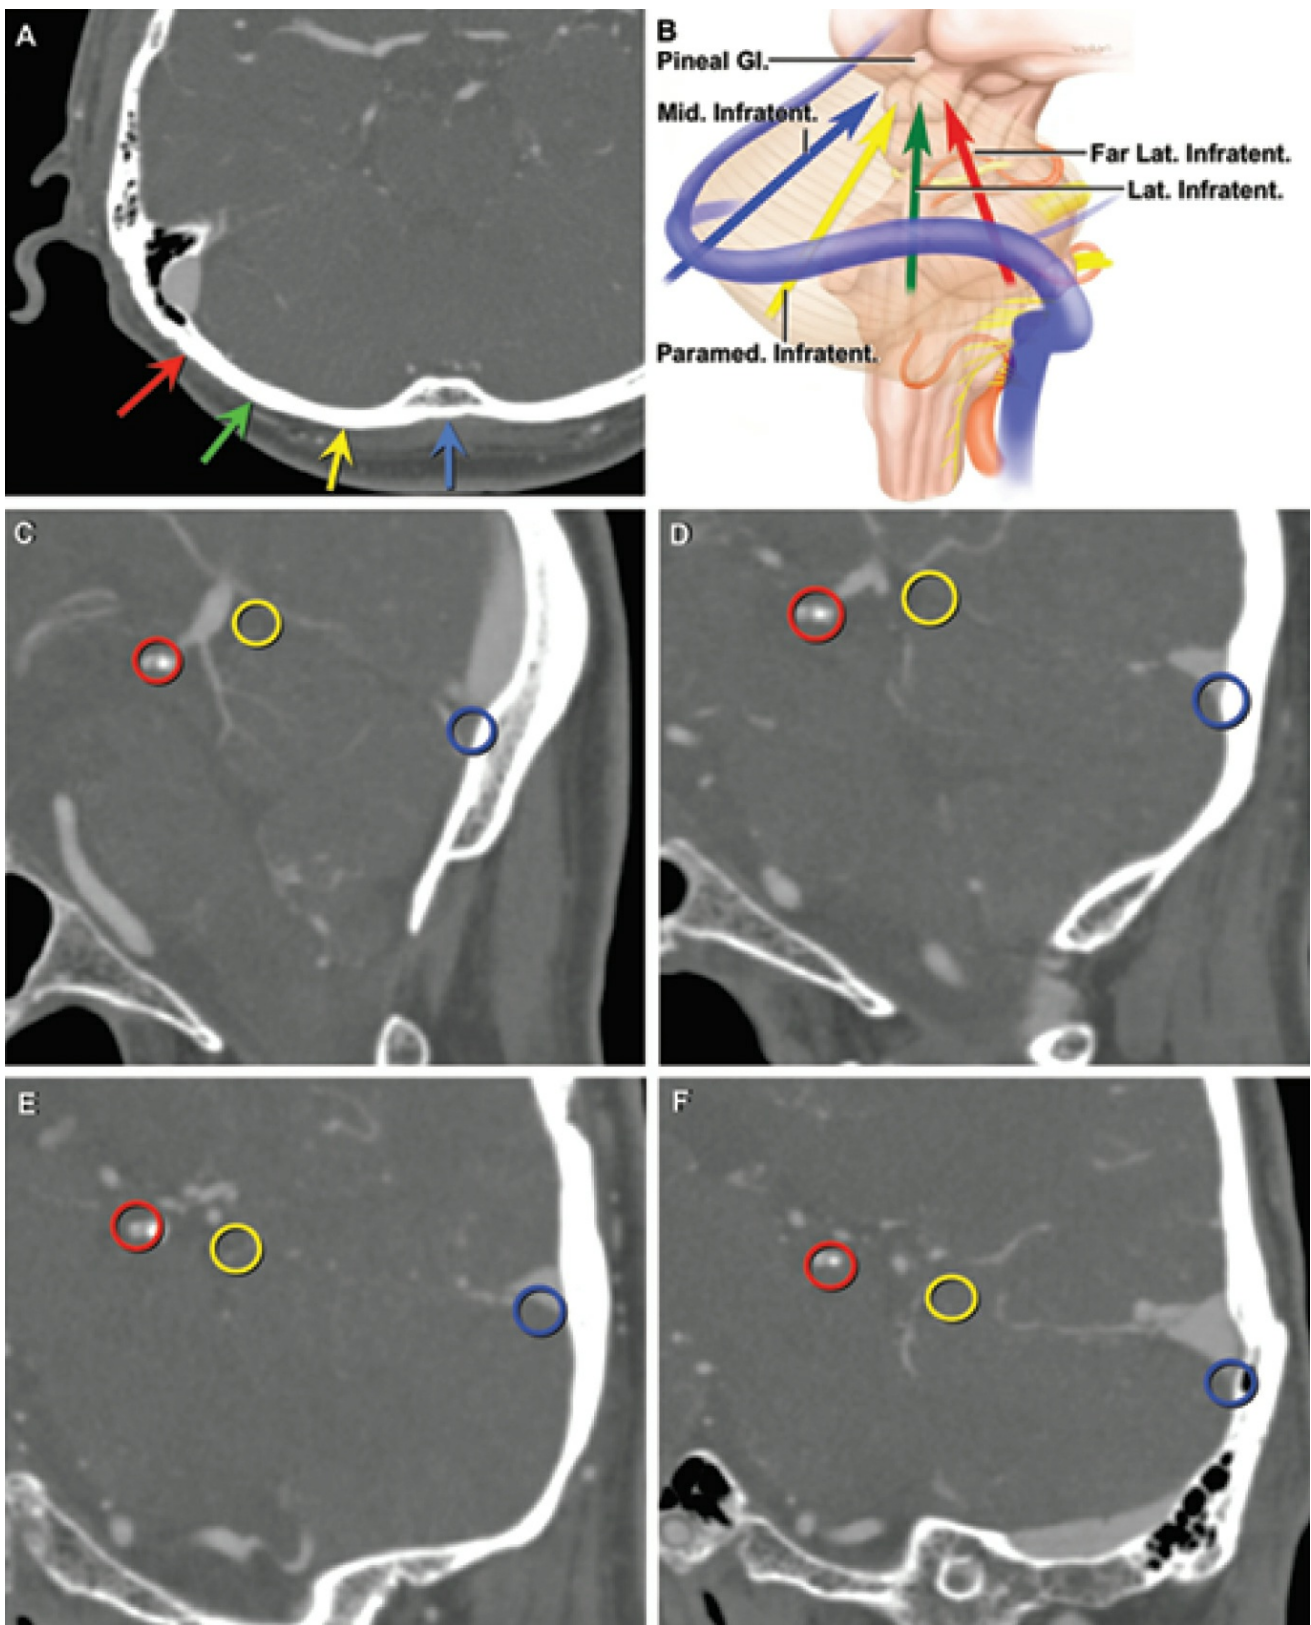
Measurements of the depth of the pineal gland and angle of the tentorial surface of the cerebellum through the midline, paramedian, lateral, and far-lateral supracerebellar infratentorial routes. A: Axial CT image at the level of the corner of the transverse and sigmoid sinuses (Plane A, the axial plane passing through the junction of the transverse and sigmoid sinuses). In examining the different supracerebellar infratentorial approaches, the distance between the inion and sigmoid
